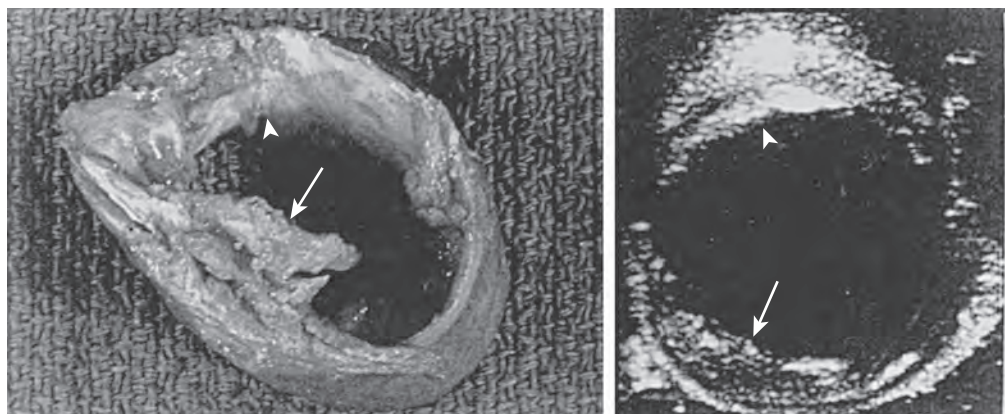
Transverse ultrasonic image of the ascending aorta and the corresponding segment of aorta in a patient with severe atherosclerosis. Note the calcification (arrowhead) and the projection of atheroma (arrow) into the lumen. (From Wareing TH, Davila-Roman VG, Barzilai B, et al. Management of the severely atherosclerotic ascending aorta during cardiac operations. A strategy for detection and treatment. *J Thorac Cardiovasc Surg.* 1992;103:453–462.)
